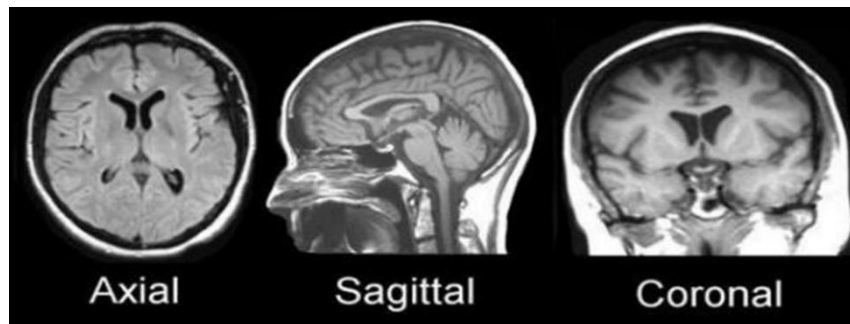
Brain MRI viewed from three directions [Ullah, Zahid & Lee, et al. (2020)]
